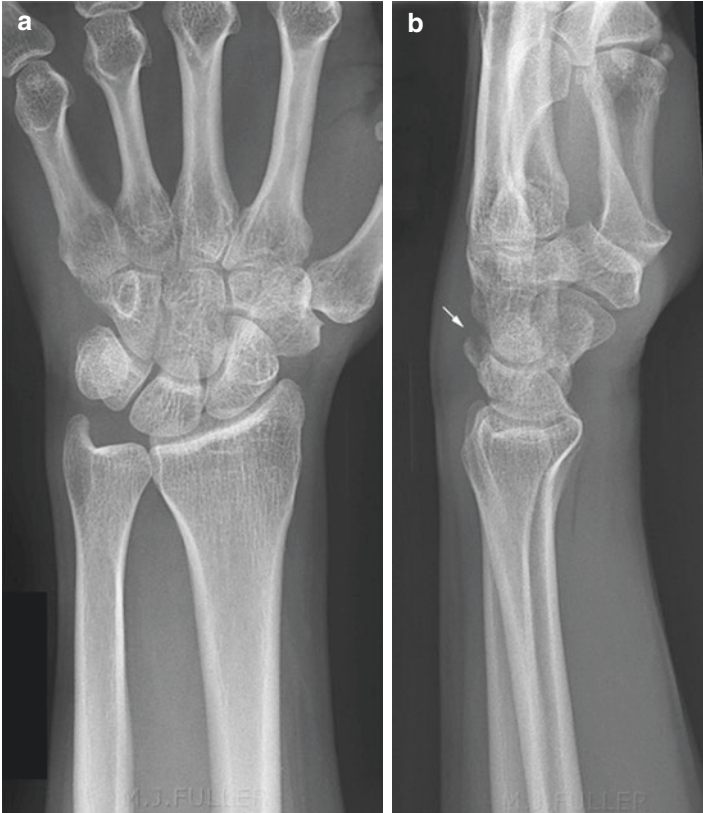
Triquetral fracture X-ray: (a) PA view, (b) lateral view, arrow points to pathognomonic dorsal chip fracture. (a, b: Used with permission from <http://www.wikiradiography.net/page/Triquetral+Fractures>)
